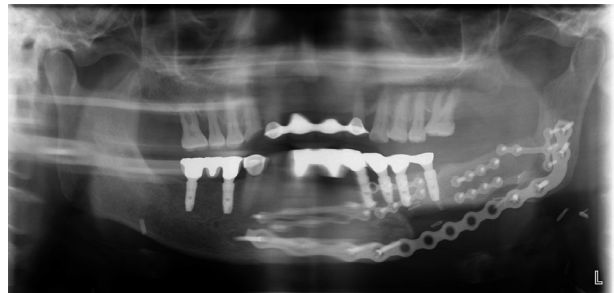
Postoperative panoramic radiograph showing three dental implants in the fibular flap with favorable crown-implant ratio.
